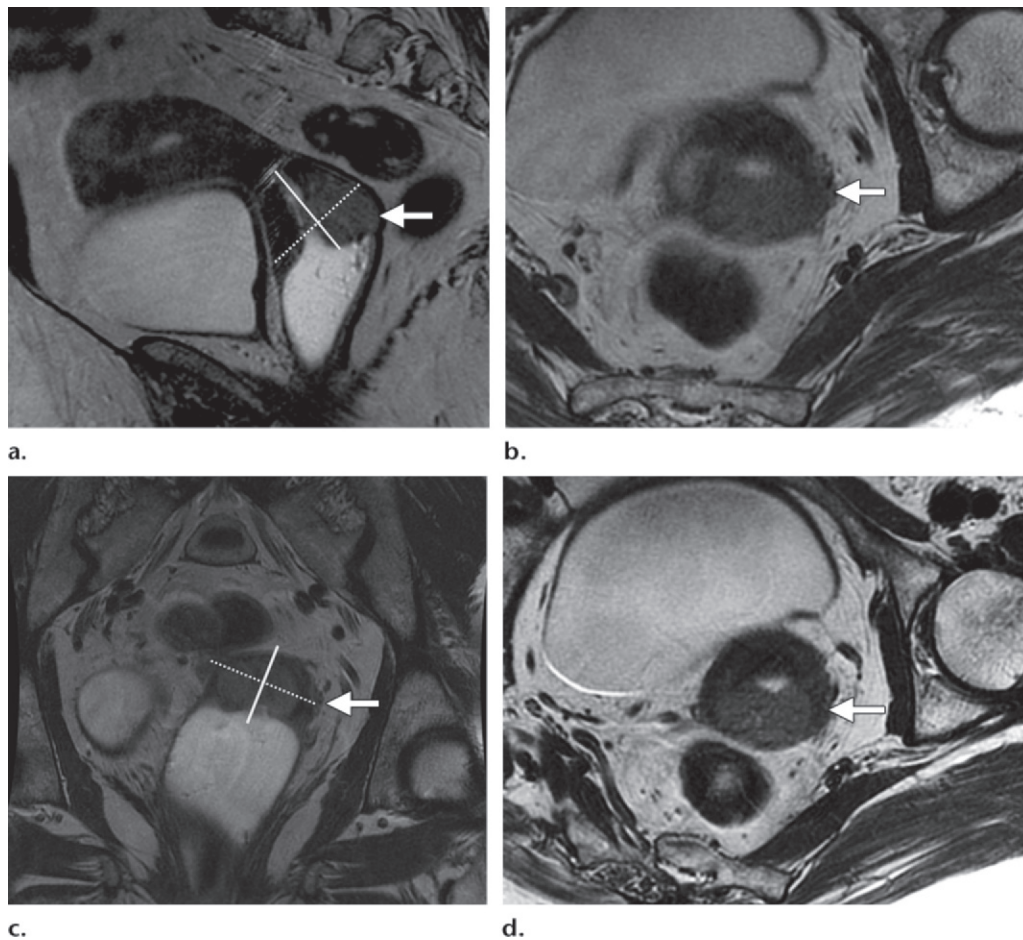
Value of double oblique high-resolution T2-weighted FRFSE MR images for depicting parametrial invasion. (a) Sagittal high-resolution T2-weighted FRFSE MR image shows an intermediate-signal-intensity mass in the posterior cervical lip (arrow) and the acquisition plane (dashed line) of oblique axial images, which were obtained perpendicular to the long axis of the cervix (solid line). (b) Axial oblique high-resolution T2-weighted FRFSE MR image obtained on the basis of sagittal T2-weighted images shows the mass in the posterior cervical lip with possible tumor infiltration into the left parametrium (arrow). (c) Coronal T2-weighted MR image shows the cervix, which angles to the left of the midline (arrow), and the angle of acquisition (dashed line) of the double oblique axial image perpendicular to the long axis of the laterally deviated cervix (solid line). (d) Double oblique T2-weighted MR image angled along the axis of the cervix on the basis of the sagittal and coronal images shows an intact cervical stroma (arrow) between the tumor and the parametrium, excluding parametrial invasion at left. Double oblique images are valuable in eliminating the effects of volume averaging.
